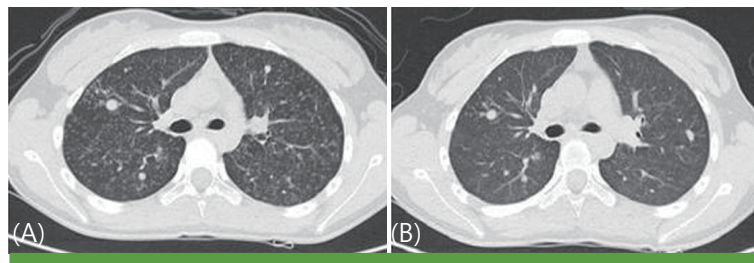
(A) Initial high-resolution chest CT. Mixed pattern of diffuse miliary pulmonary tuberculosis and active pulmonary tuberculosis. Extensive bronchogenic spread in both lungs with combined tuberculous lymphadenitis at both hila and the mediastinum. (B) Follow-up high-resolution chest CT. Compared with previous chest CT, there is improvement of the mixed pattern of diffuse miliary pulmonary tuberculosis and active pulmonary tuberculosis. Abbreviation: CT, computed tomography
